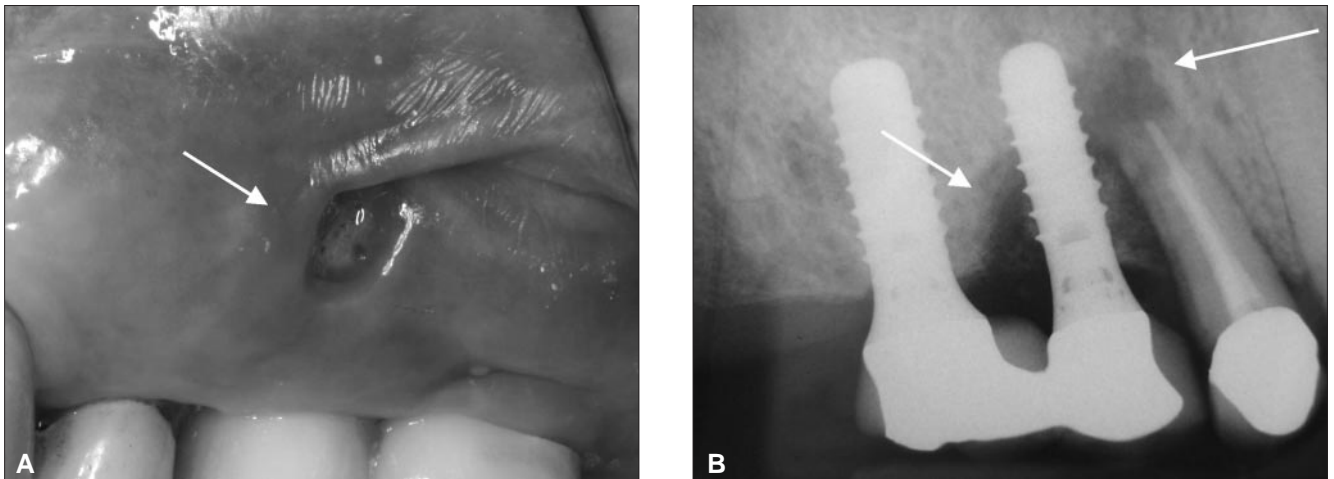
8 months into maintenance therapy. Patient remains asymptomatic. A. Observe through a mirror the buccal surface of the area being treated with laser therapy and local plaque debridement. Observe that there is now clear evidence of necrotic bone exposure, characterizing stage II BON. However the area is clean and there is no evidence of pus (arrow). B. Radiographic appearance of the same area showing signs of improvement, with apparent better calcification in the area (arrows).
